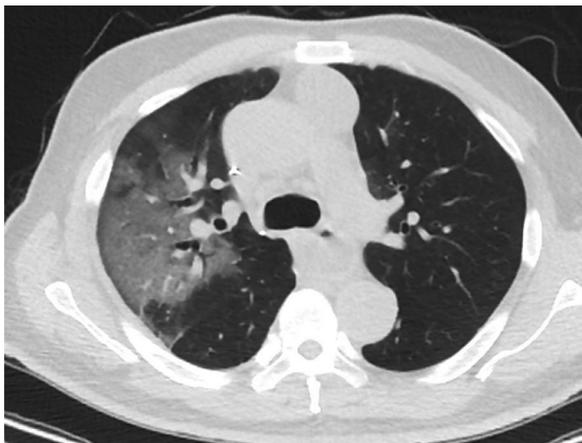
Axial CT demonstrates predominantly ground-glass right upper lobar opacification in the acute phase, without evidence of significant organization or scarring.
